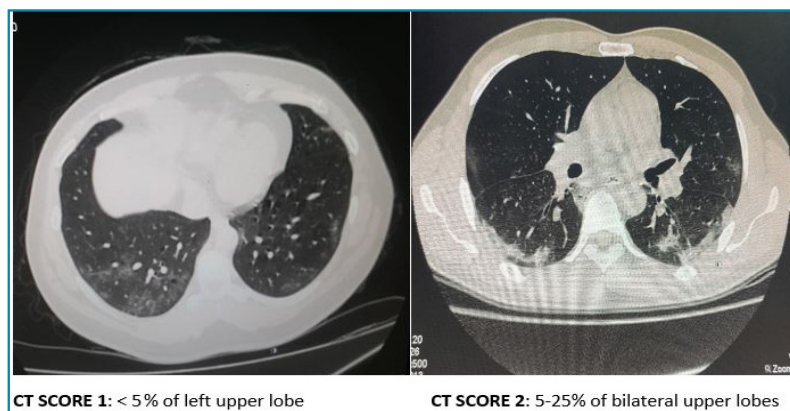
(a): CT severity score (1, 2)
